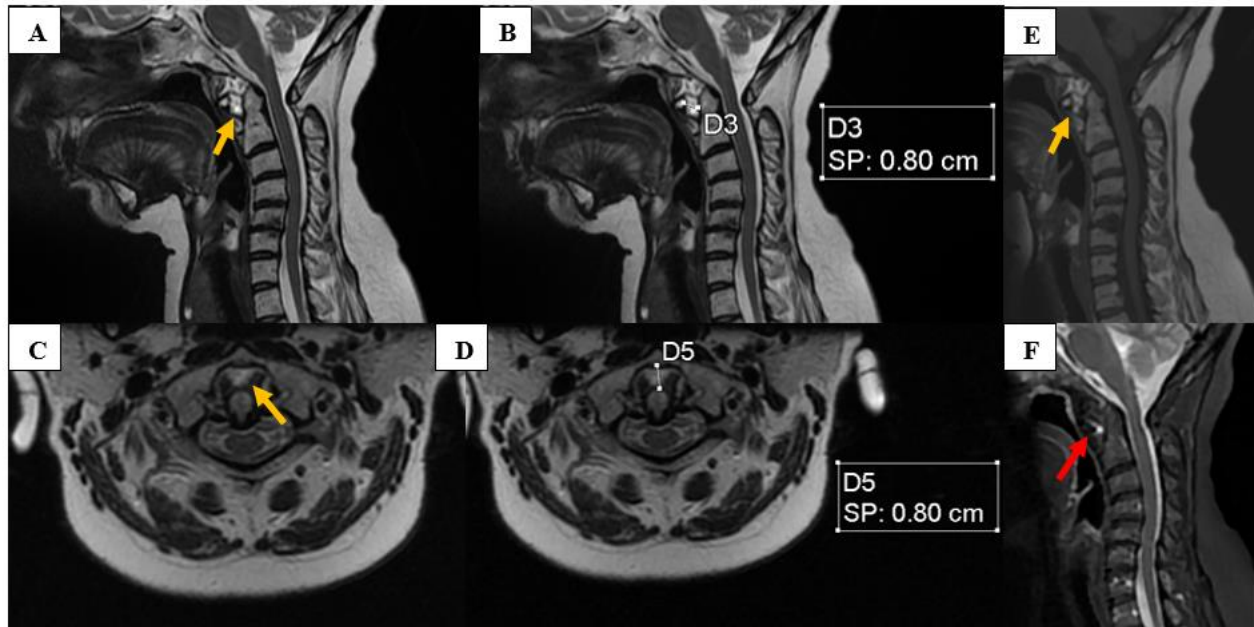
Sagittal (A, B) and axial (C, D) T2 sequences demonstrating widening of the atlantodental interval measuring 8 mm associated with soft tissue mass consistent with synovial pannus within this space (yellow arrows) appearing isointense on T1-weighted images (E), hyperintense on T2 weighted images (A, B, C, D). STIR images (F) showing peri-dental synovitis (red arrow)
